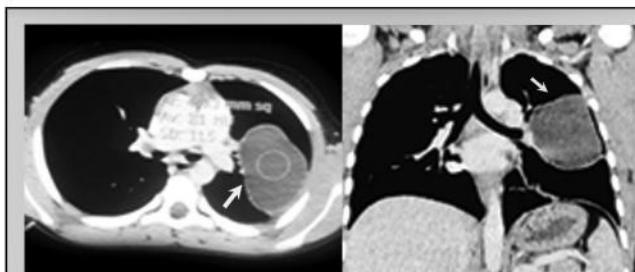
Chest CT with contrast shows a cystic lesion 11 x 9 cm at left side of lung.
